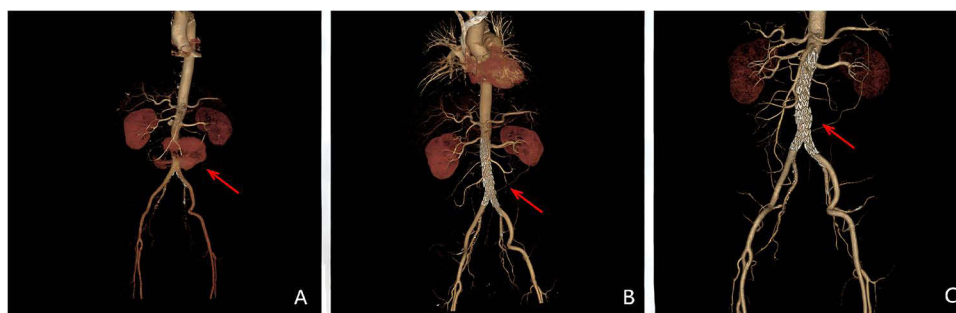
Presents serial computed tomography angiography (CTA) findings of the aorta. (A) shows the preoperative CTA image, where a red arrow indicates the site of hemorrhage. (B) demonstrates the postoperative CTA image, with a red arrow indicating satisfactory placement of the stent. (C), obtained one month after discharge, reveals significant regression of the retroperitoneal hematoma, characterized by marked reduction in both volume and density, with the red arrow pointing to the area of resolution.
